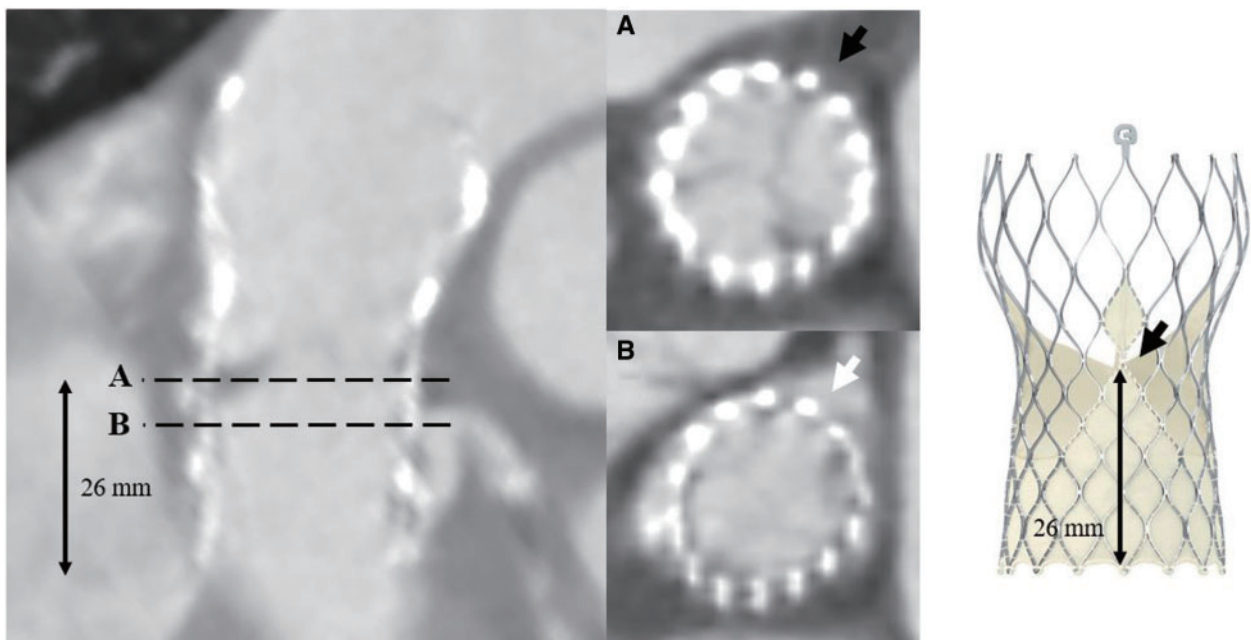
Contrast-enhanced computed tomography showing the distance between the waist of the Evolut R valve (A) and the level of the left coronary cusp (B). The arrows indicate a commissural post of the valve at each level.
